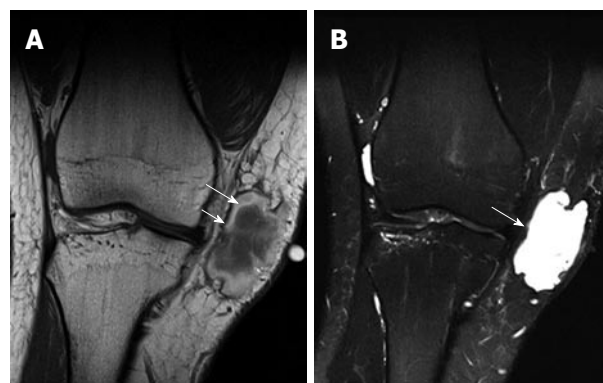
Early subacute hematoma. A: Coronal T1-weighted; B: T2-weighted MR image of the knee. On T1-weighted image, there is a hyperintensity of extracellular methemoglobin at the periphery (long arrow) of the hematoma (which is seen 2-7 d after injury). Note a very thin low-signal-intensity rim at the outermost layer of the hematoma, indicating hemosiderin (short arrow). B: Coronal T2-weighted MR image shows overall hyperintensity of the hematoma (arrow), exception made for a very thin low-signal-intensity peripheral rim caused by hemosiderin.
